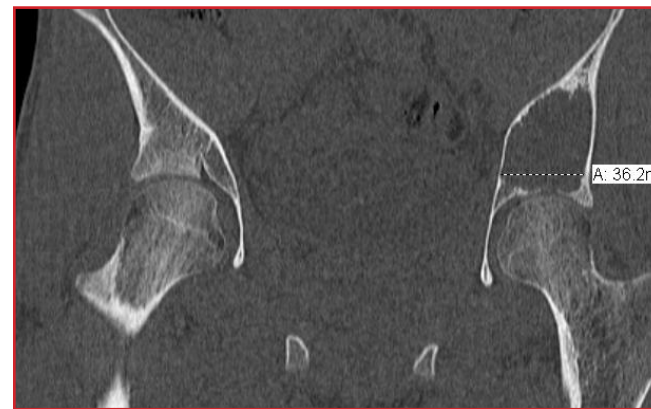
Successive computed tomography images of the ilium obtained after the second procedure and pelvic angiography show a recurrent, large lytic lesion in the left ilium.
